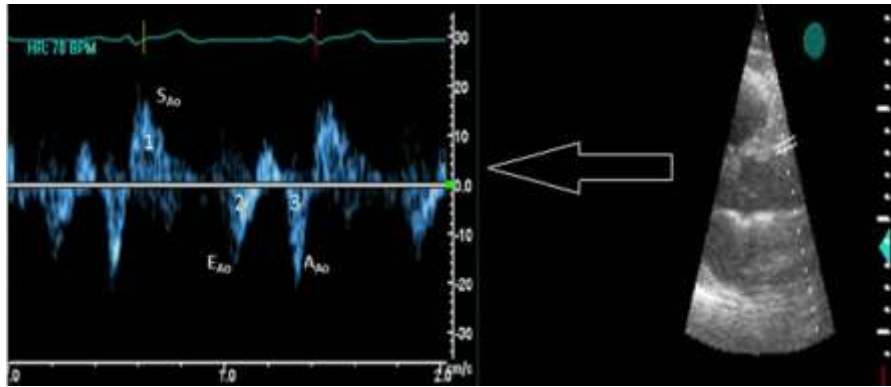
Tissue assessment of the upper aortic wall velocity Doppler imaging. 1=Sa_o: systolic aortic upper wall velocity while .2=Ea_o: early diastolic aortic upper wall velocity; 3=Aa_o: late . . diastolic aortic upper wall velocity^[15]
